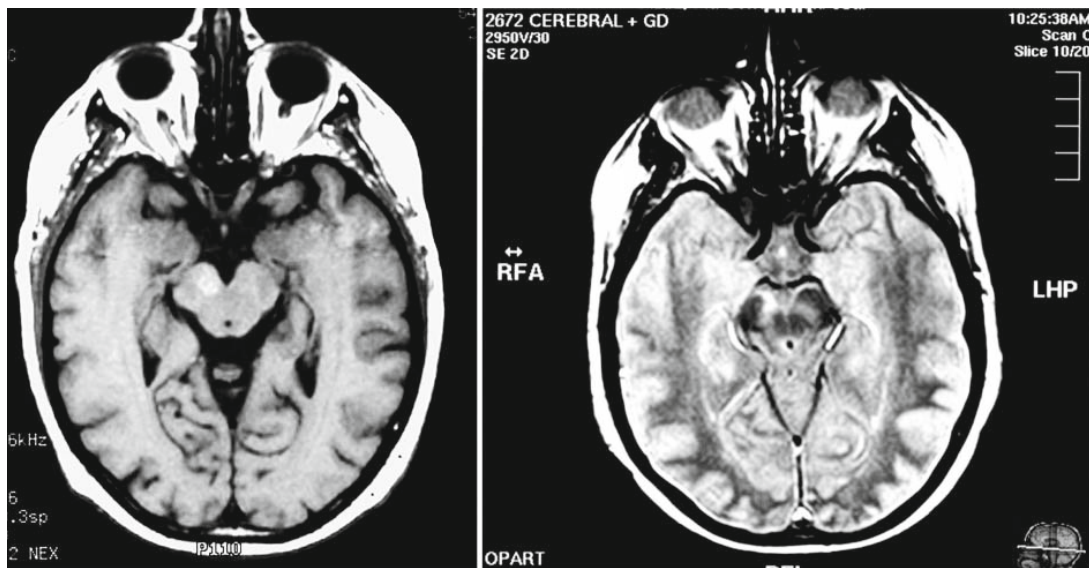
Magnetic Resonance image in October 2003 (left) and August 2009 (right)
